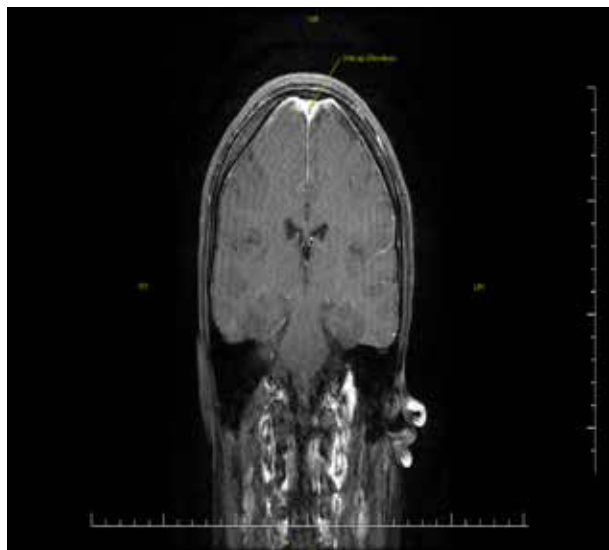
Brain magnetic resonance imaging showing superior sagittal sinus thrombosis as delta sign in coronal view.
